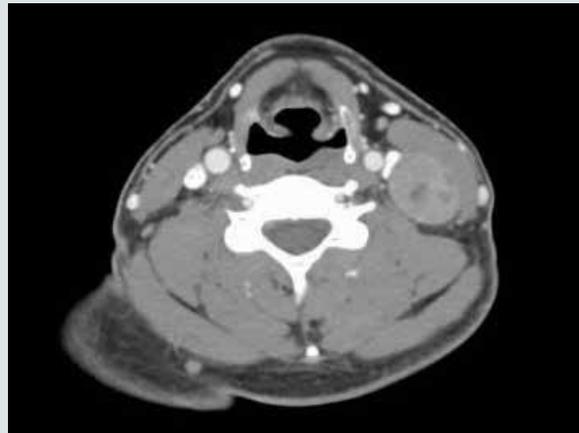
Contrasted CT of the neck showing a left-sided cervical lymph node.
